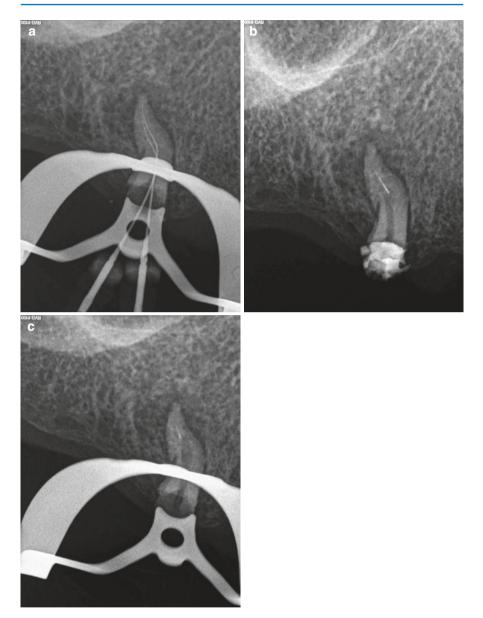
Secondary breakage of NiTi fragment. (a) Working length radiograph. (b) Staging platform and exposure of approximately 1–2 mm of the coronal end of the NiTi fragment. (c) Secondary fracture of the initial fragment following the use of an RT3 tip (EMS) at a low power setting
